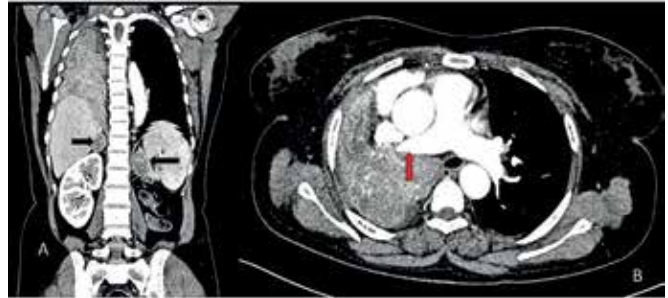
Contrast enhanced computed tomography of thorax and abdomen along the coronal plane (A) showing complete collapse of the right lung, heterogeneous masses in bilateral adrenal glands suggestive of metastases (black arrows) and an absent left kidney and transverse section of thorax (B) showing a large heterogeneous mass in the right hilar area involving the right main stem bronchus resulting in complete collapse of the right lung and encasement of the right pulmonary artery (red arrow).
